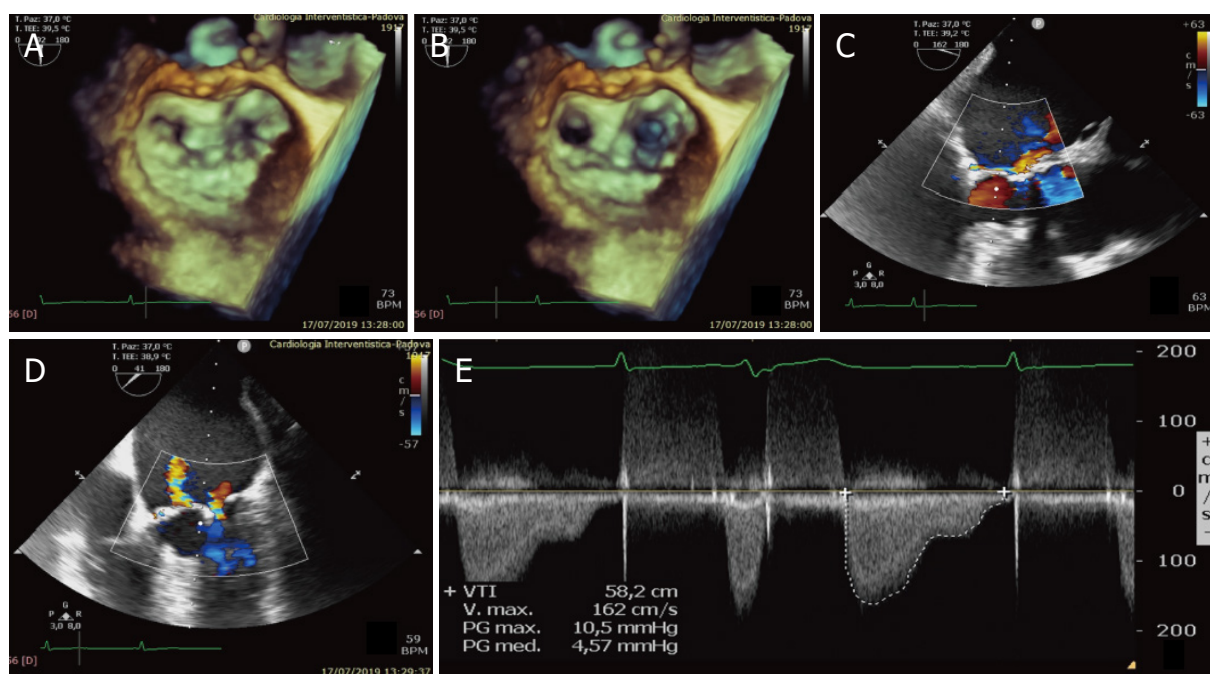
Final result. The 3D TEE shows the new "double orifice" mitral valve (A, B) with mild residual mitral regurgitation (C, D); continuous doppler (E) shows a final transvalvular gradient less than 5 mmHg
